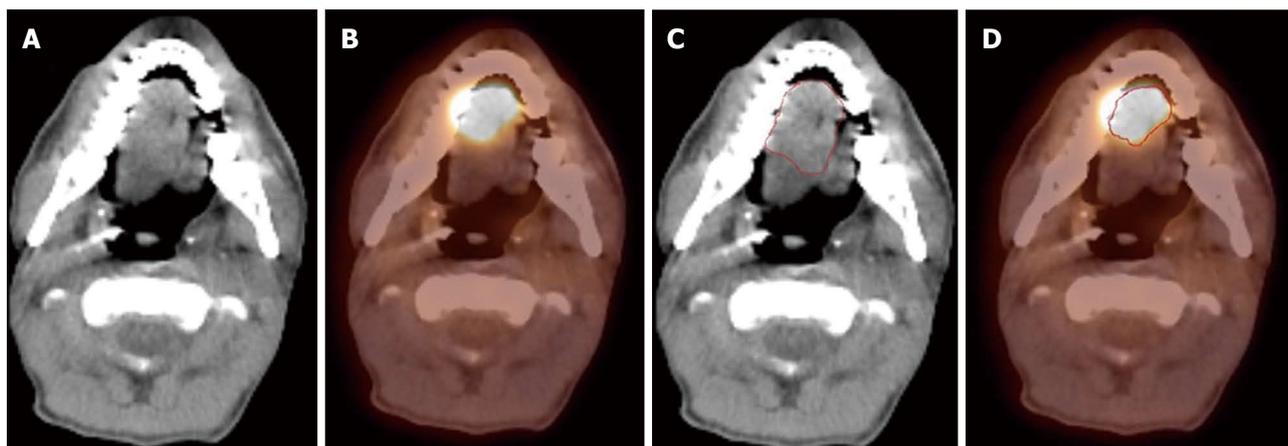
A patient with oral tongue cancer. The edge of the tumor was not very clear in the computed tomography (CT) image (A), but more obvious in the PET image (B). Gross tumor volume was outlined based on CT scan (C) vs with fluorodeoxyglucose positron emission tomography/CT (D). The volume included is larger with CT alone.
